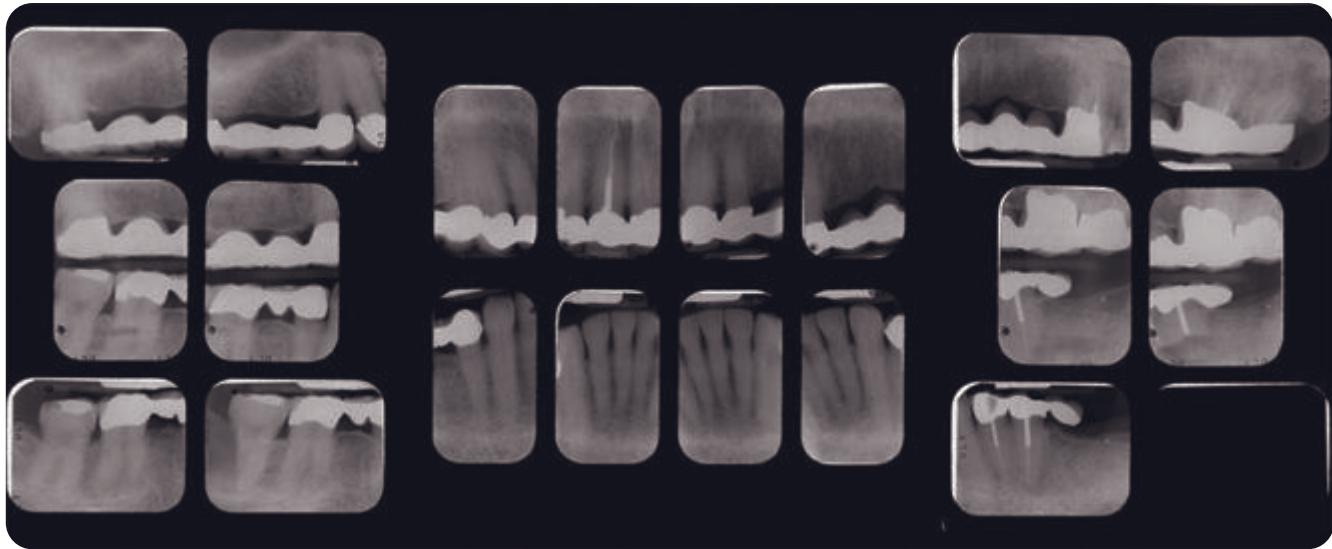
Preoperative full mouth radiographic series.
